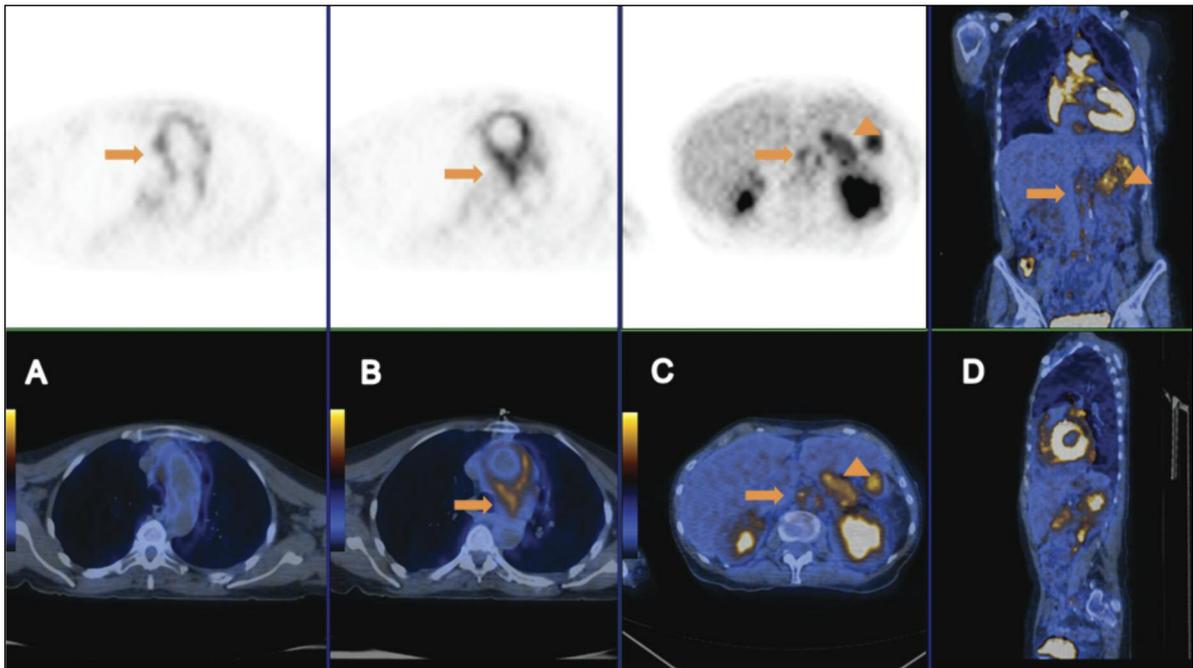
F18-Fluorodeoxyglucose (FDG) positive emission tomography. Images A, B and C (axial views) showing increased tracer uptake in the tissue surrounding the ascending aorta and the abdominal aorta (arrow). There is also an increased heterogeneous tracer uptake in the body and tail of the pancreas, suggestive of a pancreatitis (arrowhead). Image D (coronal and sagittal views) showing increased uptake in the ascending aorta and a segmented uptake in the abdominal aorta (big arrow) and in the body of the pancreas suggestive of a pancreatitis (arrowhead).
